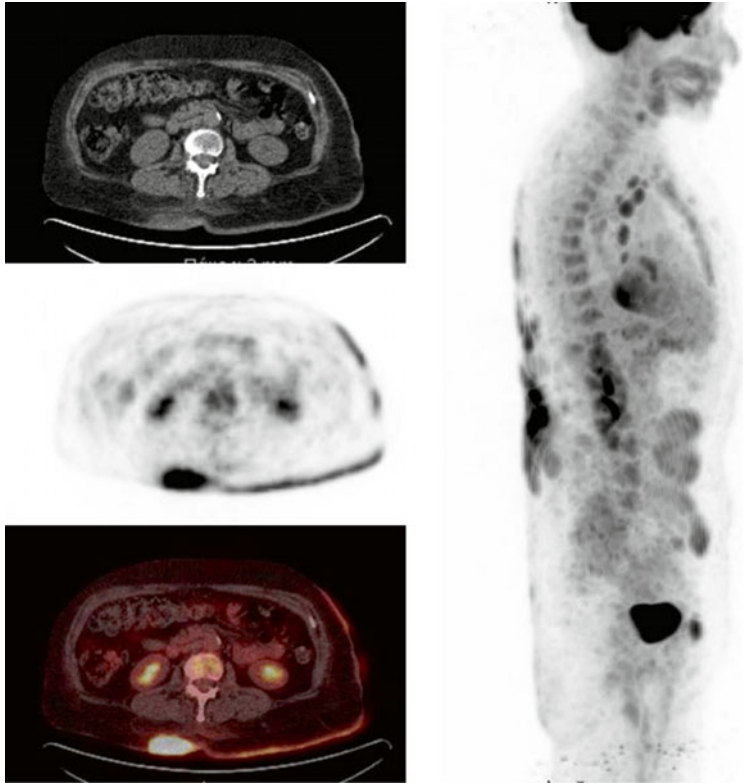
CT (*upper row*), PET (*middle row*), fused PET/CT, and MIP-PET images: multiple cutaneous hypermetabolic lesions at the trunk
